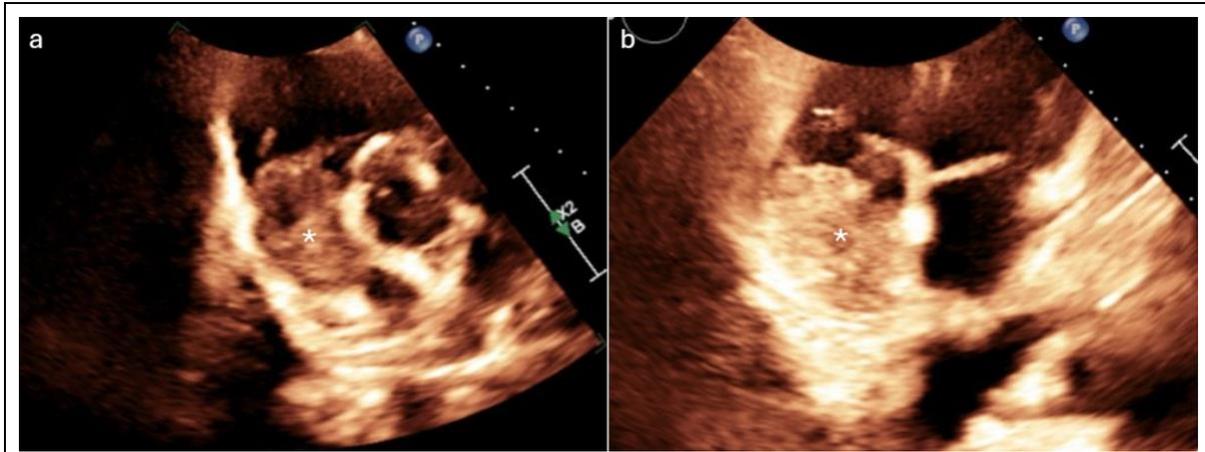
(a): Parasternal Short Axis (PSAX) at level of aortic valve with large mass in right atrium;
